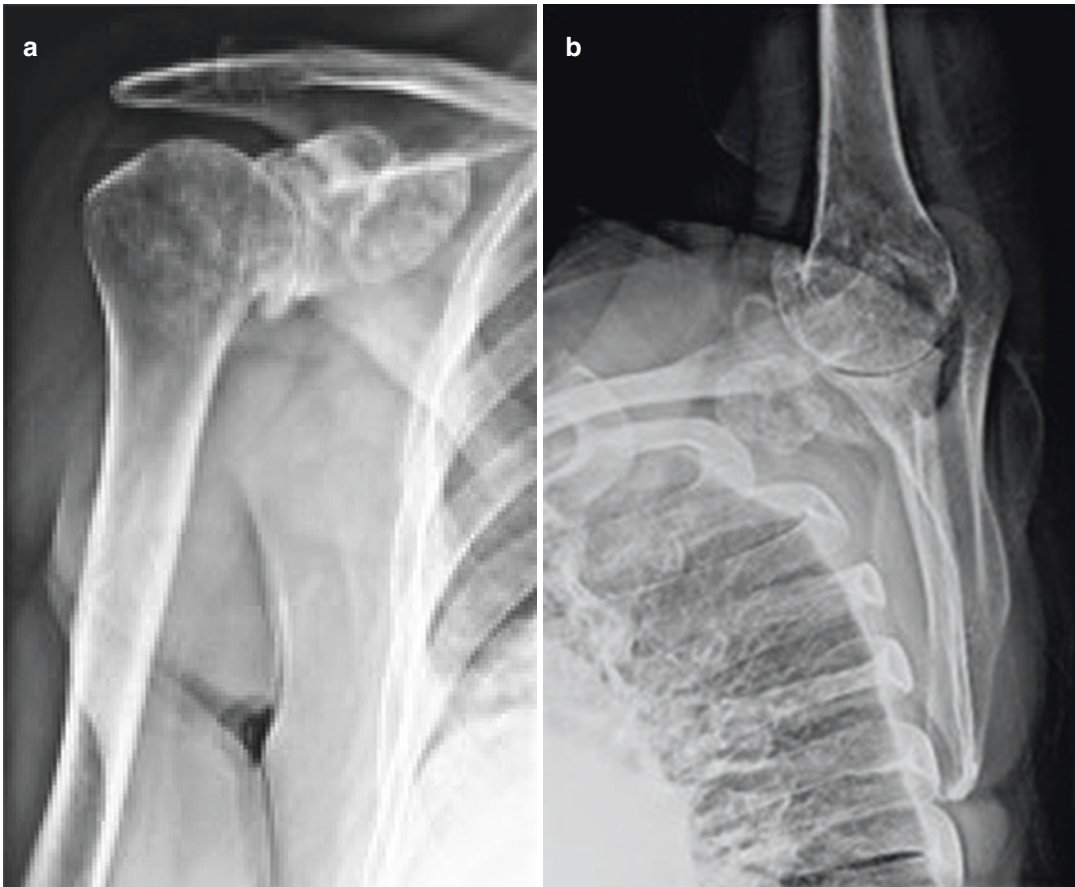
Right shoulder. Preoperative X-rays: anteroposterior view (a) and axillary view (b)
